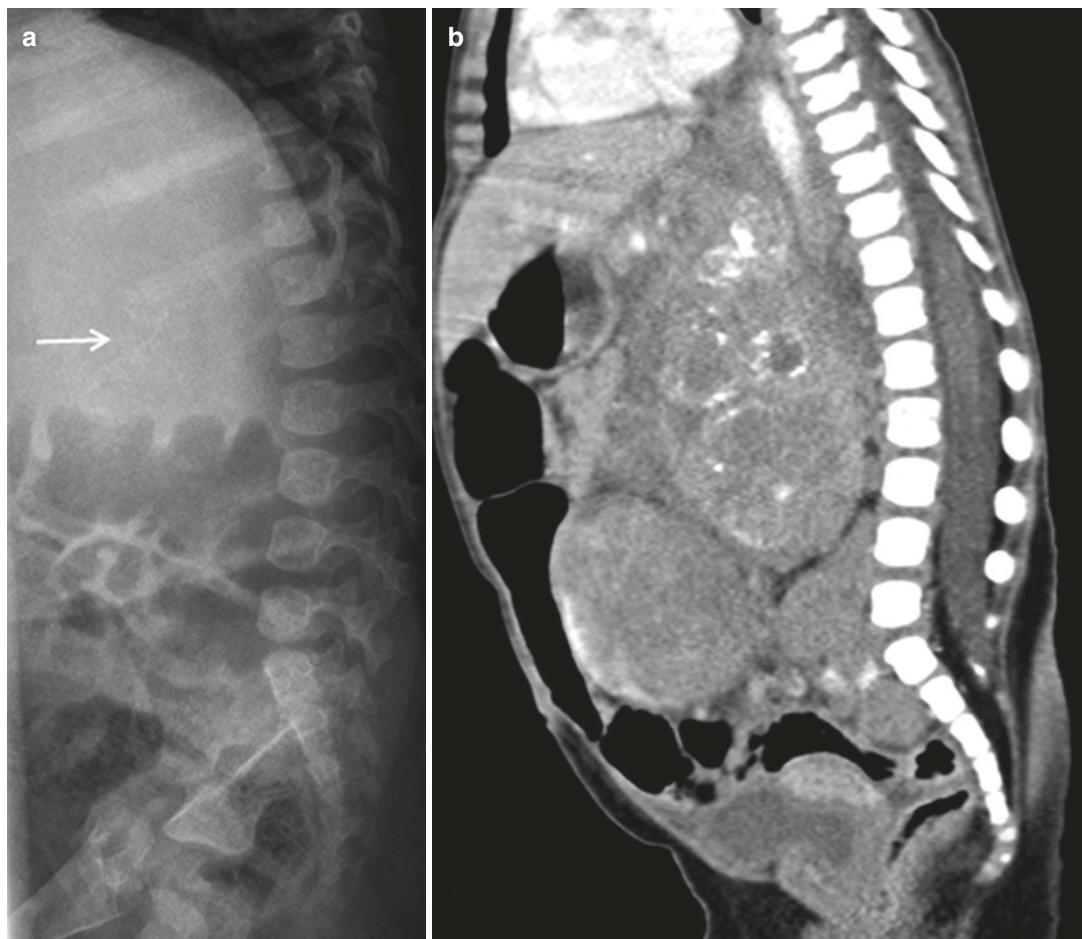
(a) Lateral radiograph of the lumbar spine of a 10-month-old girl showing punctate calcifications (arrow) projecting over the liver. (b) CT showing a large
